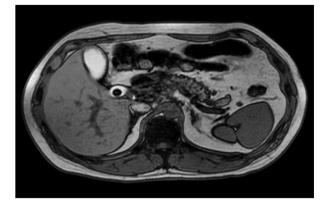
Magnetic resonance imaging showing thickening of the gallbladder wall without bile duct obstruction. This finding points to acute cholecystitis.
